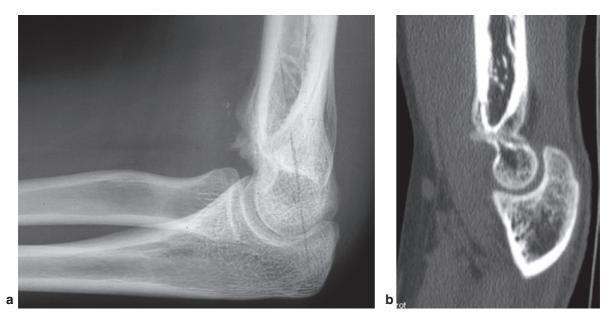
Extension malunion: loss of normal anteversion $(30-40^\circ)$ of the lower end of the humerus. Range of flexion is limited to 100° . X-ray (a) and CT scan (b)
